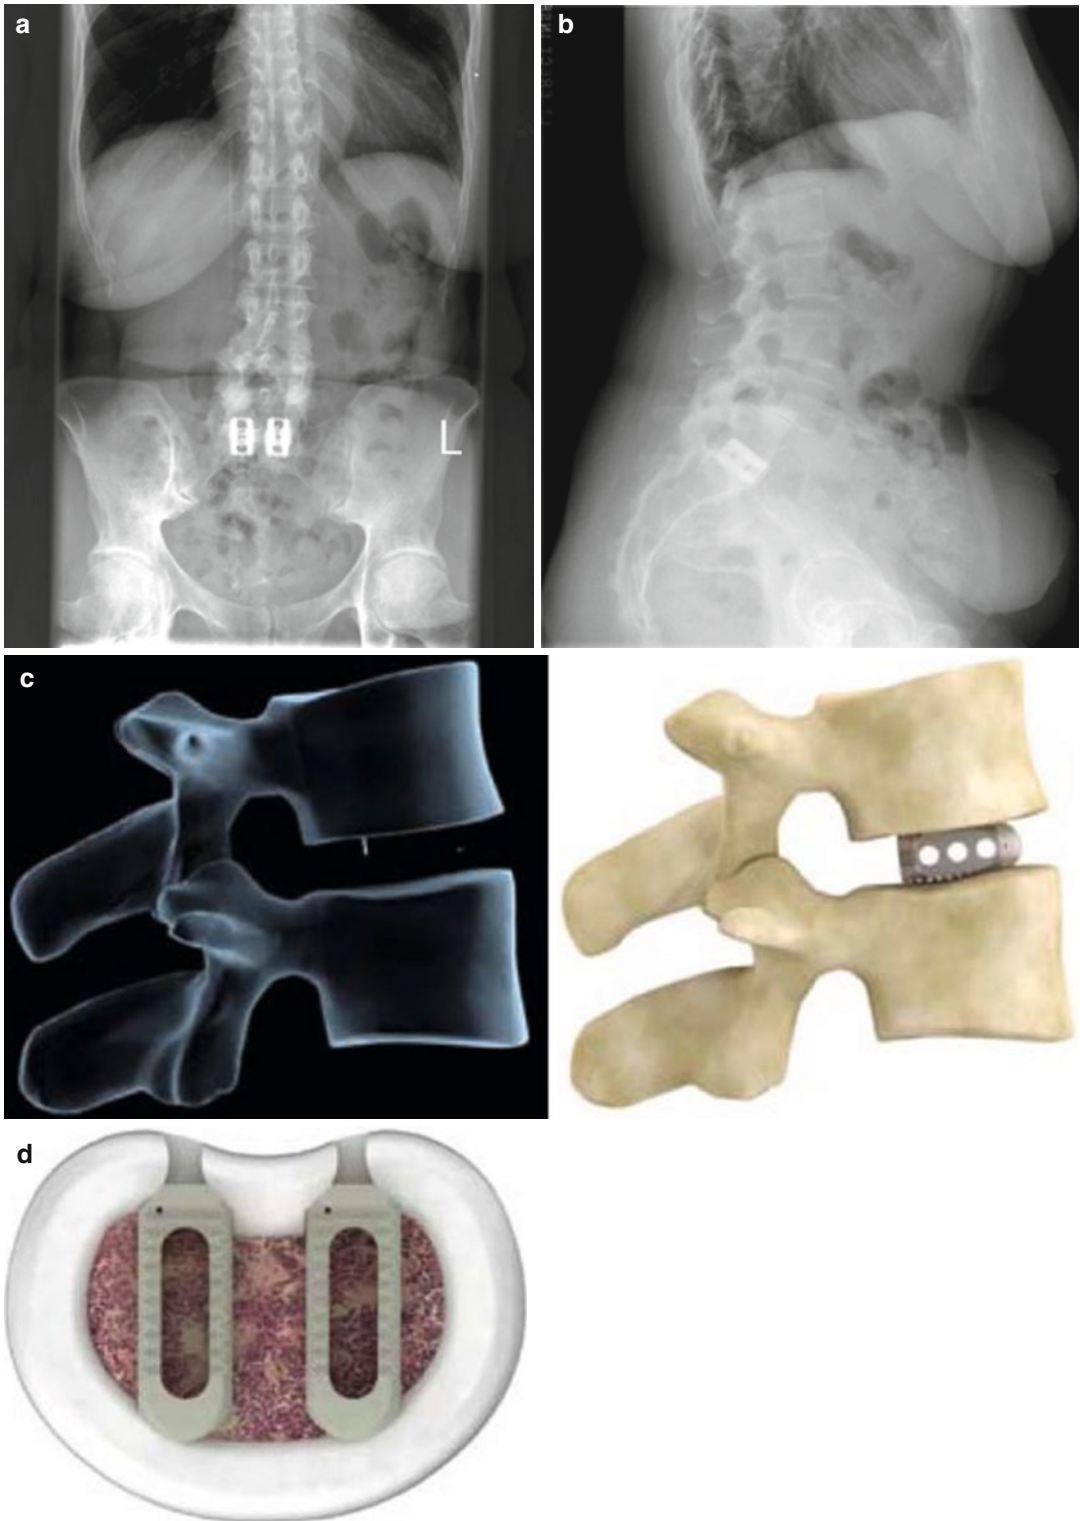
(a, b) Shown here are postoperative AP and lateral radiographs of a posterior lumbar interbody fusion. (c) This image depicts the placement of an interbody device between two lumbar vertebrae in a posterior
